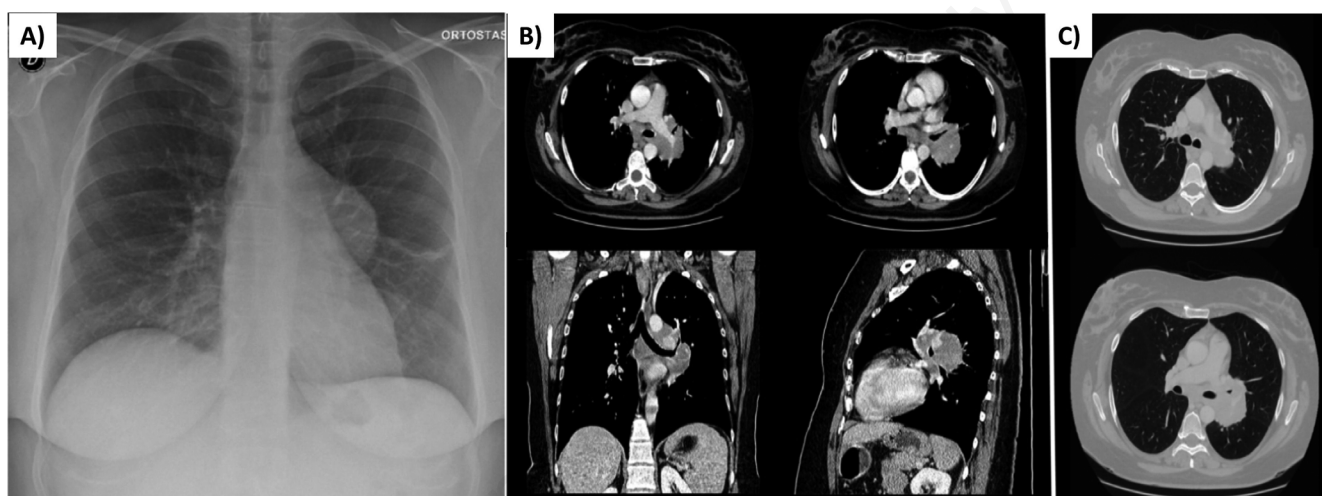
A) Chest X-ray: left hilar lesion; mediastinum (B) and lung parenchyma (C) on chest CT-scan.
